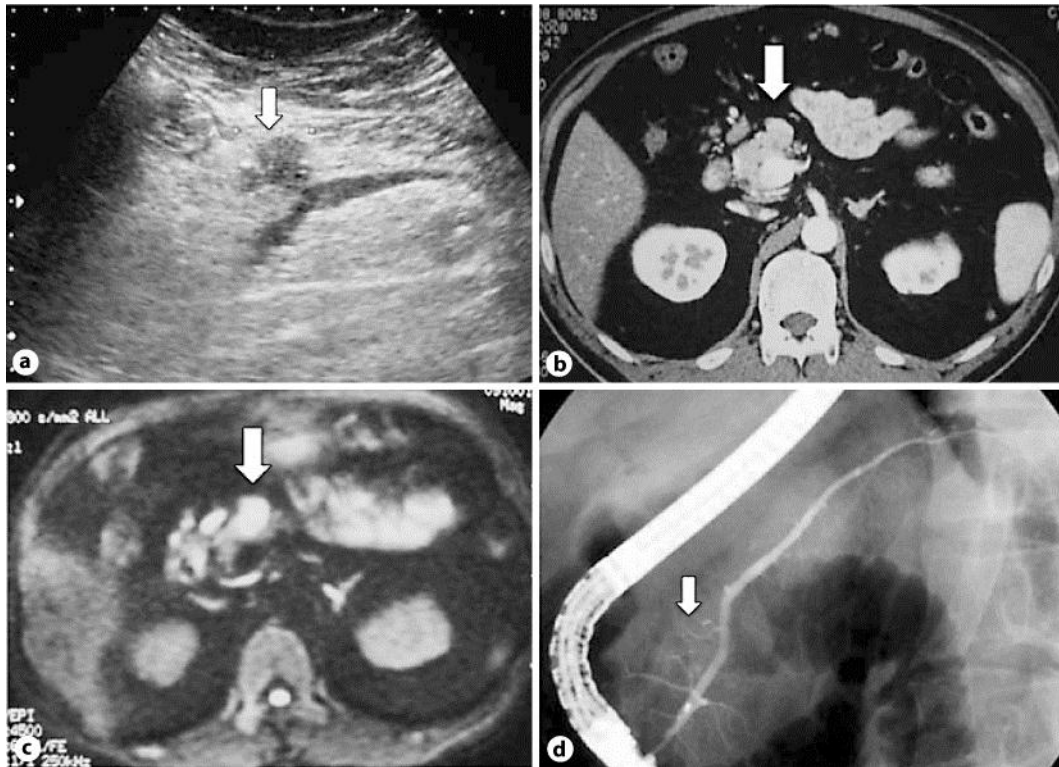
a Abdominal ultrasonography showed a 15 mm hypoechoic mass located in the pancreatic body without dilatation of the main pancreatic duct (arrow). b Computed tomography revealed a tumor in the pancreatic body without any contrast enhancement (arrow). c Magnetic resonance imaging demonstrated the mass to be hyperintense on diffusion-weighted image (arrow). d Endoscopic retrograde cholangiopancreatography revealed slight dilatation of a branch of the pancreatic duct in the pancreatic body without stricture of the main pancreatic duct and the common bile duct (arrow).
